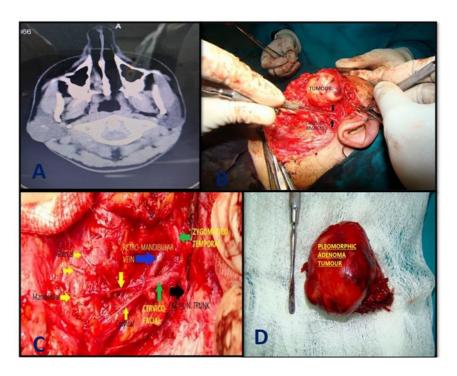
A: axial section of CT scan showing lobulated soft tissue mass within the posterior part of the superficial lobe of the left parotid gland, B: showing modified Blair incision with anterograde dissection identifying the main trunk of the facial nerve, C: total superficial parotidectomy with preservation of all facial nerve branches, D: the tumor mass with a cuff of normal parotid gland tissue.
